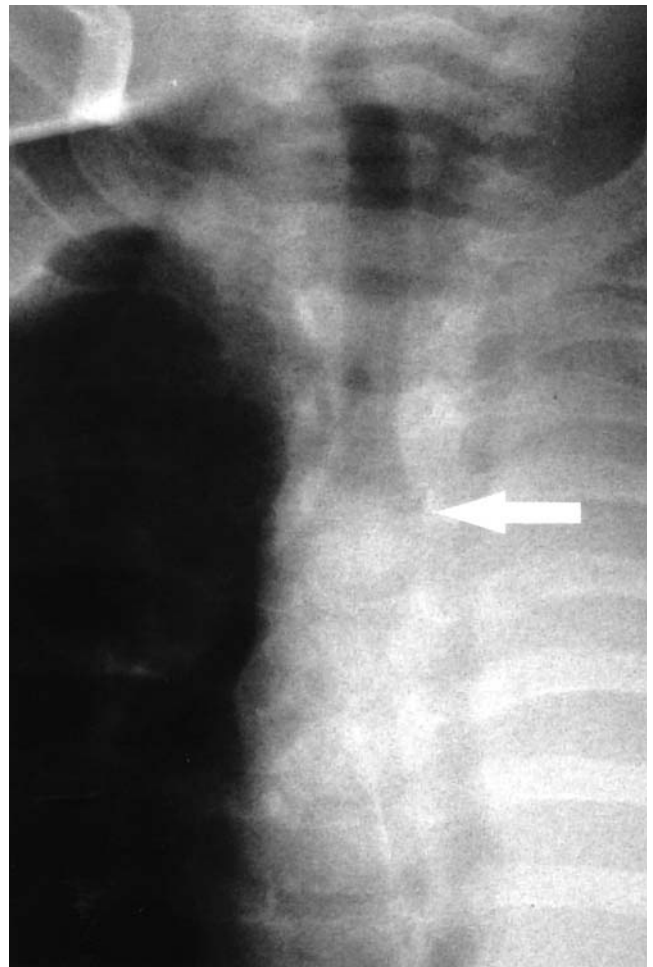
Penetrated AP chest radiograph showing abrupt 'cut-off' of the left main bronchus, approximately 1 cm from its origin (arrow).
